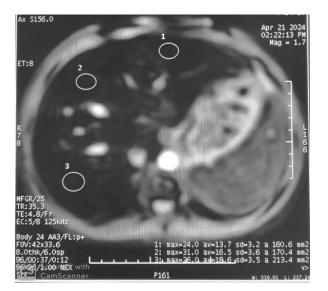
11 years old female child diagnosed with thalassemia major disease. Clinically, the patient exhibited hepatosplenomegaly and anemia on regular blood transfusion every 21-23 days. Laboratory investigation revealed elevation in serum ferritin level 7255 ng/ml [normal range: 21.8-247.6 ng/ml] along with elevated bilirubin 1.9 mg/dl [normal range: 0.1-1.2 mg/dl] and normal albumin 4.2 mg/dl [normal range: 3.4-5.4 mg/dl]. notably, elevated AST 52 IU/L [normal range: 10-34 IU/L] and elevated ALT 52 IU/L [normal range: 10-44 IU/L]. MRI [T2*] performed on liver resulting in low T2* [16.3 ms] which means LIC 0.91 ng/g denoting sever hepatic iron overload.
